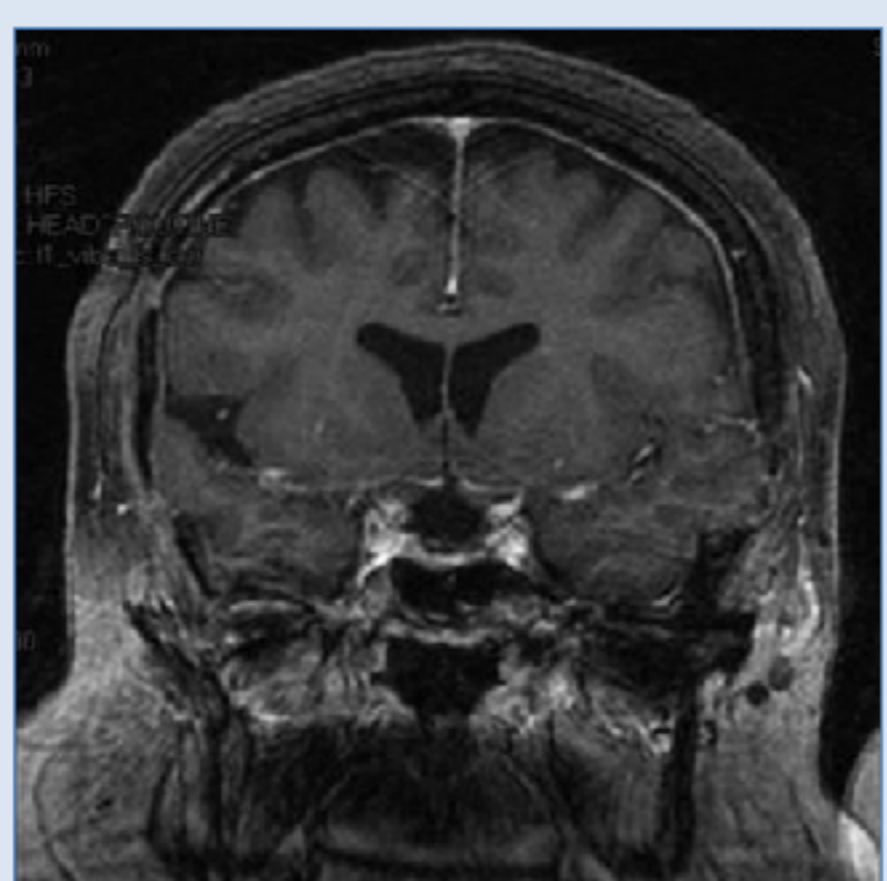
Postoperative cranial MRI
